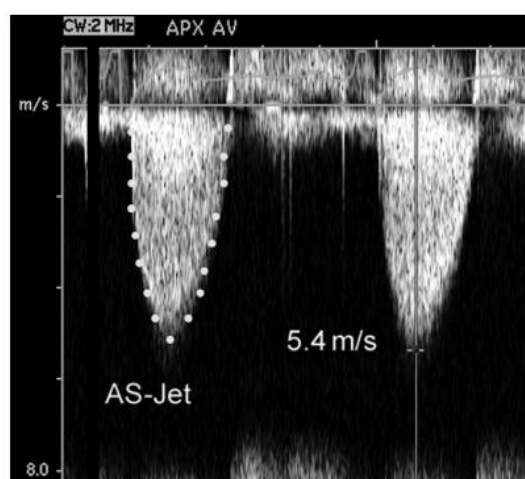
Continuous wave Doppler of severe aortic stenosis jet showing maximum jet velocity and tracing of velocity curve for mean pressure gradient calculation (Baumgartner et al., 2009).
